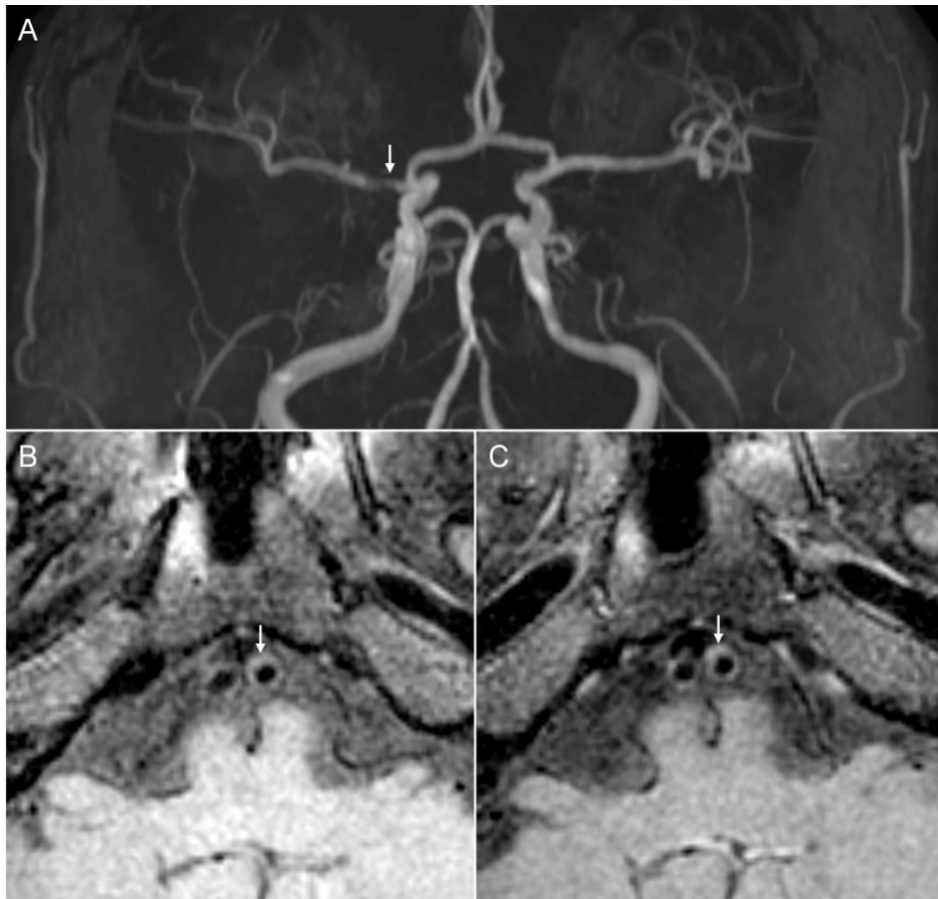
A typical case of an asymptomatic atherosclerotic plaque in the VA. A, a symptomatic atherosclerotic stenosis of the right MCA-M1 segment on MRA imaging (white arrow). B and C, an eccentric, focal plaque in the left VA as an asymptomatic atherosclerotic lesion before and after administering contrast on T1w imaging, respectively (white arrows). MCA, middle cerebral artery; MRA, magnetic resonance angiography; T1w, T1-weighted; VA, vertebral artery.
